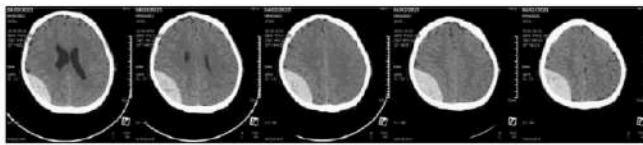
Preoperative CT-Scan results
